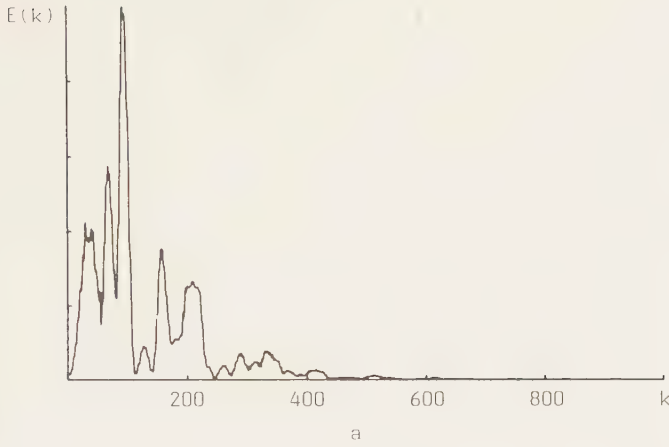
Short-time energy $E(k)$ of the ultrasonic signal (Fig. 1.6a) and $\ln(1/E(k))$ with a straight mean-squares line (Fig. 1.6b) for a broadband transducer.
